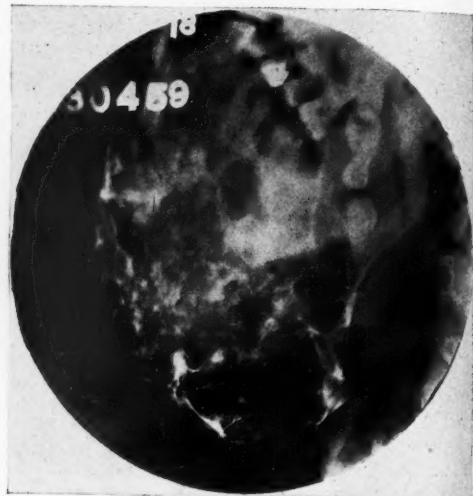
(Case A230459).—*Fibro-osteoma of the lower jaw*. Huge fibro-osteoma of almost the entire lower jaw. Age of patient, twenty-five years. The condition had lasted fifteen years. The tumor involved the body of the jaw and both sides anterior to the angle, and filled the floor of the mouth anteriorly, displacing the tongue. The tumor had developed into the shape of the upper alveolar process and palate. Note the character of the tumor in the roentgenogram.
